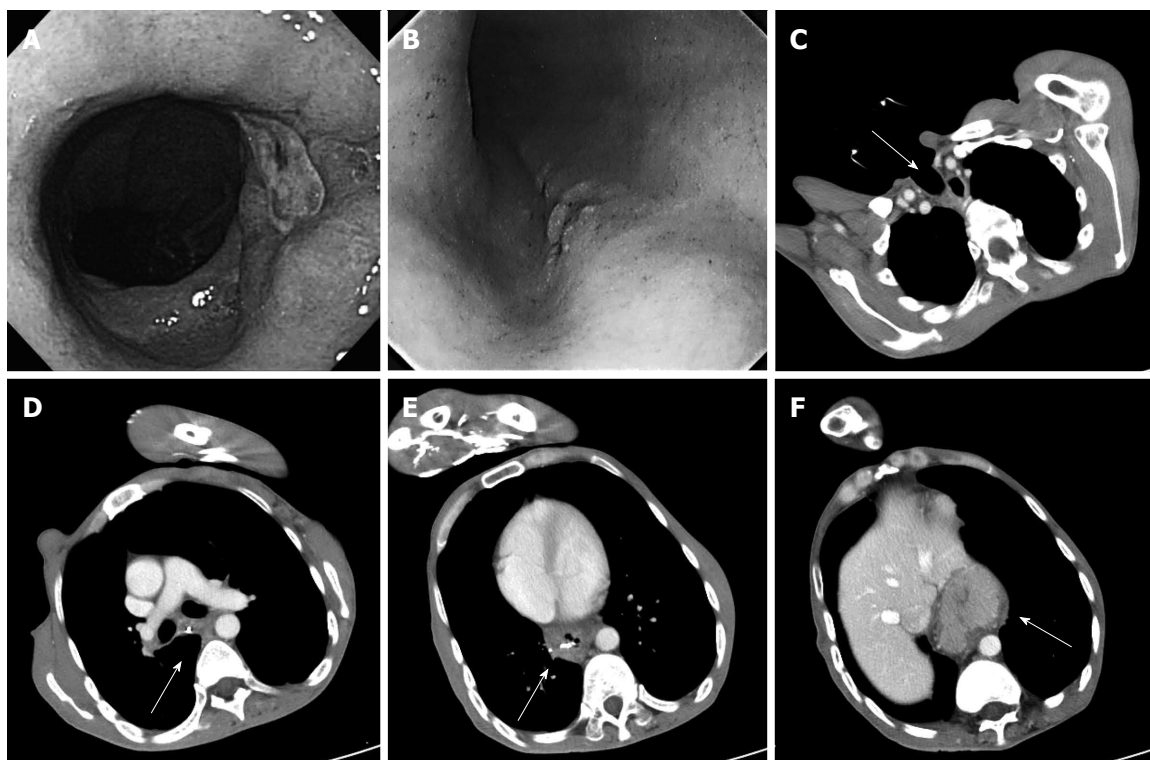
Endoscopy findings (A, B) and computed tomography findings (C-F). A: An ulcerative lesion was found in a hiatal hernia 30 cm from an incisor; B: 0-IIc type esophageal cancer was detected 25 cm from an incisor; There was severe deformity of the trunk caused by kyphosis and muscular contractures (C-F); C: The arrow points to the permanent tracheal stoma; D: The arrow points to the metal clip near the 0-IIc type esophageal cancer; E: The arrow points to the metal clip near the ulcerative lesion in hiatal hernia; F: The arrow points to the sliding hiatal hernia.
